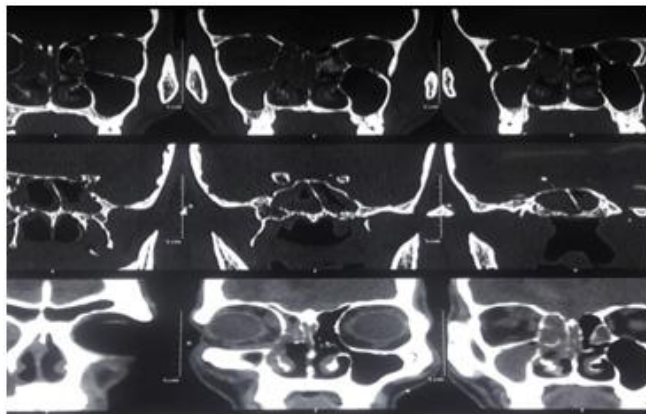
CT PNS showing sinus involvement
